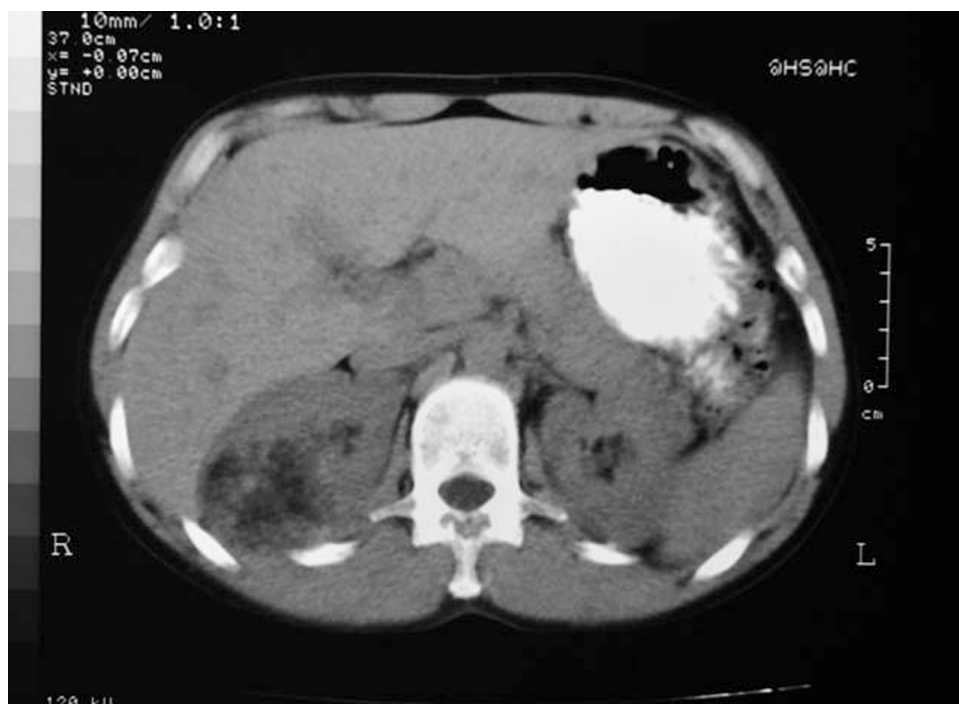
CT shows well-demarcated mass of the upper pole of the right kidney with mixed soft tissue and fatty tissue elements.
